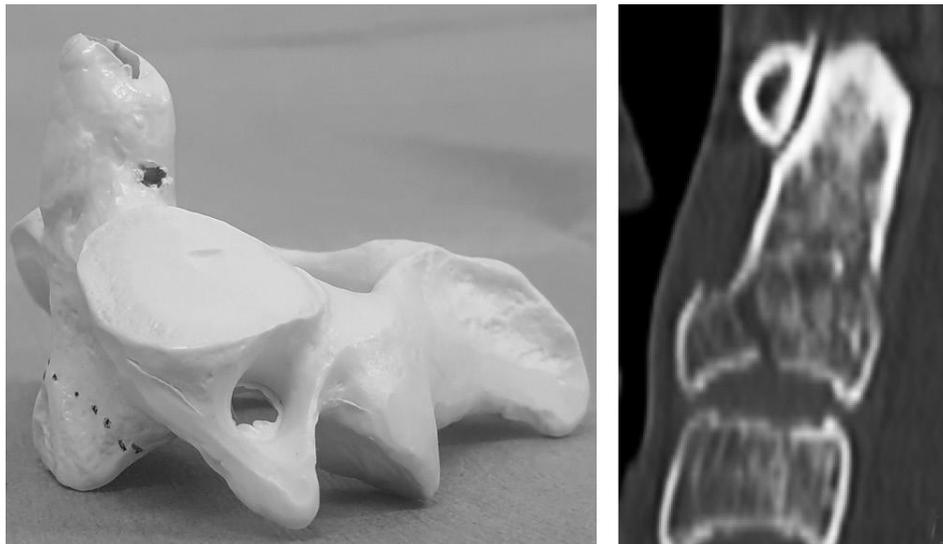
Transverse-type C2 vertebral body fracture depicted on an anatomical skeleton model and CT scan. The purple dotted line is the fracture line, originating from the medial side or the middle of the superior articular process and extending to the contralateral side of the vertebral body (A-B).
